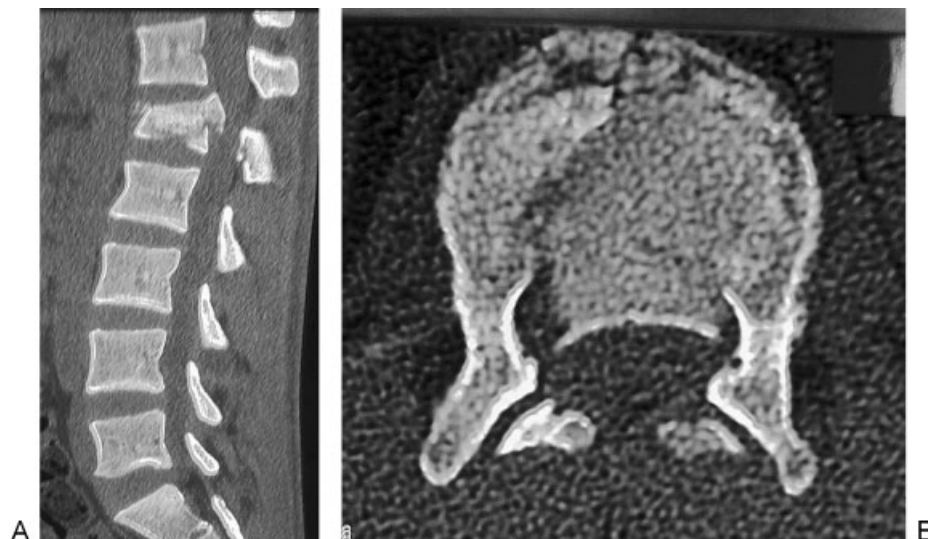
CT scan sagittal (A) and axial (B) sections show fractured L-1 body with intracanalicular bone fragments.
